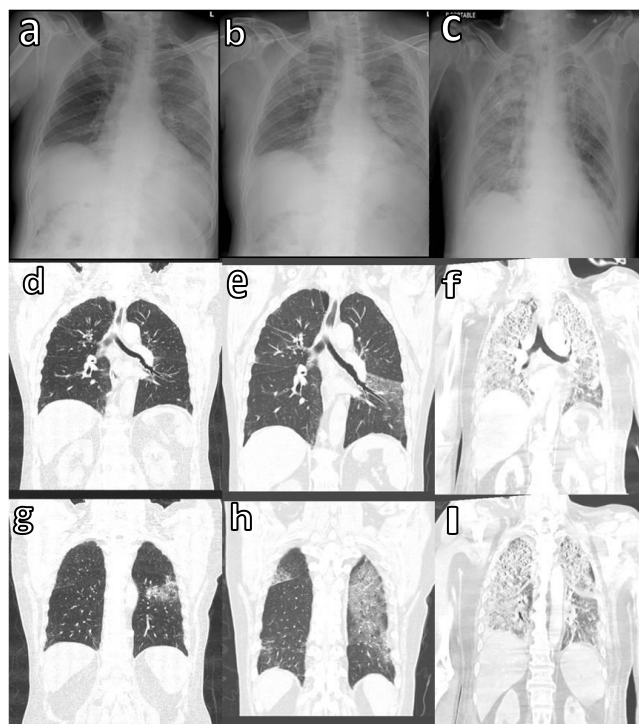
Radiologic findings of the patient. Chest radiography on day 2 (A), chest radiography on day 6 (B), Chest radiography on day 15 (C), chest computed tomography on day 2 (D and G), computed tomography on day 6 (E and H), chest computed tomography on 15 (F and I)
